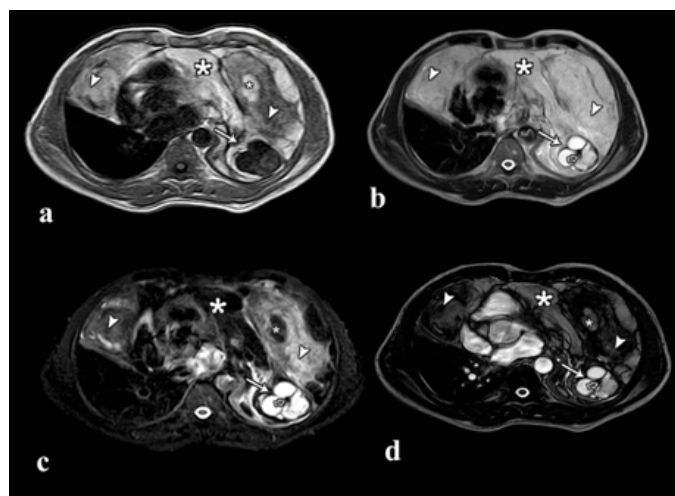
(a) Axial MRI T1W scan, (b) T2W scan, (c) Fat suppressed T2W and (d) BTFE images at the level of ventricles showing heterogeneous mass with solid component (arrow head), fat (\*), cystic area (solid arrow) and nodular calcification (open arrow), occupying anterior half of right hemithorax and complete left hemithorax with pericardial invasion.
